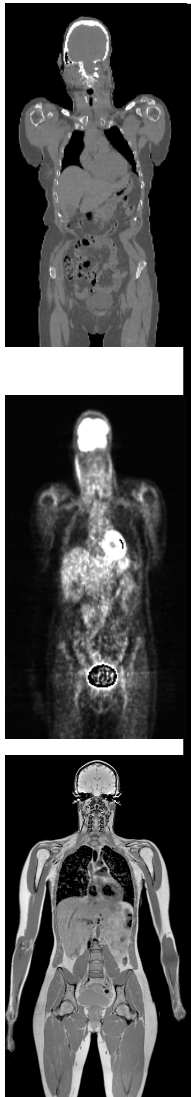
Central coronal slices extracted from acquisitions on three women by X-ray Computed Tomography, Positron Emission Tomography, and Magnetic Resonance Imaging.
